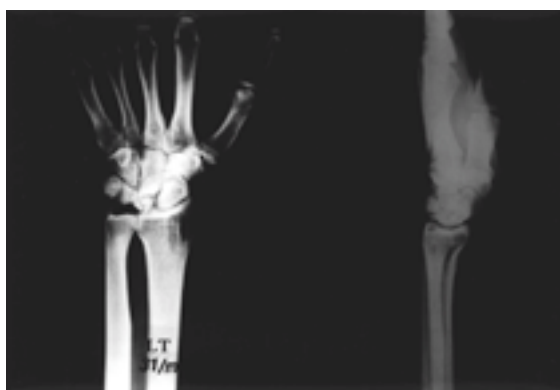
Anteroposterior and lateral view of wrist at 28 months after scaphocapitate fusion. Radiograph show good union.
